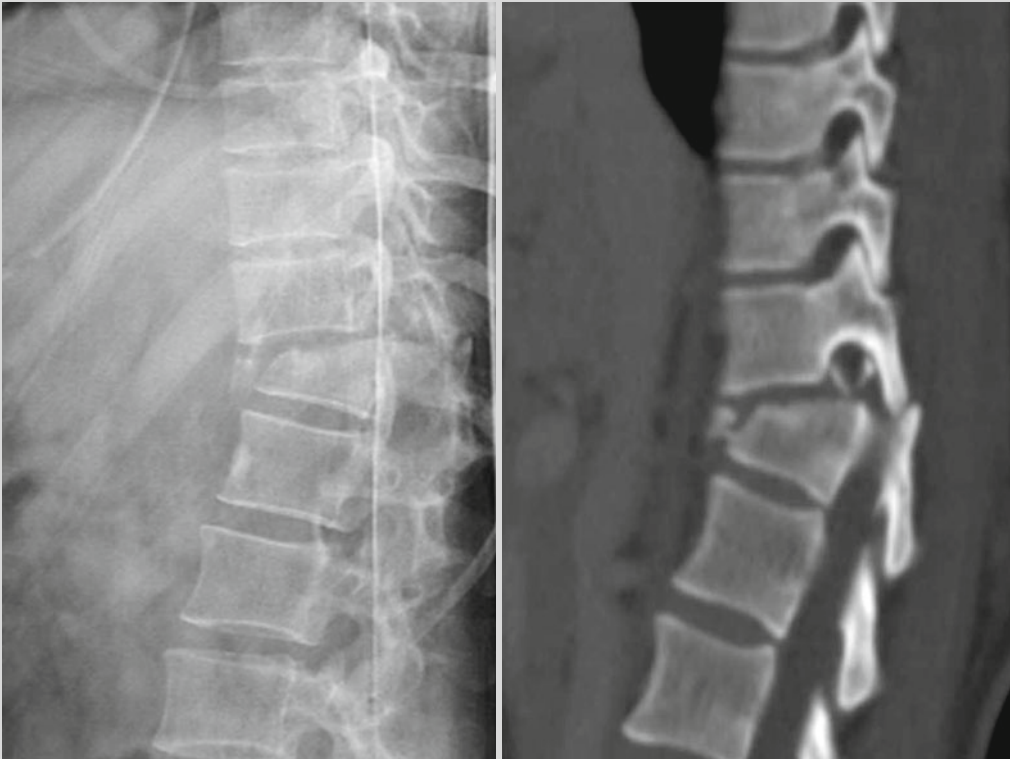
Portable-lateral radiograph and parasagittal computed tomography (CT) images demonstrating thoracolumbar fracture-dislocation with bilateral facet fracture-dislocations and translational deformity
